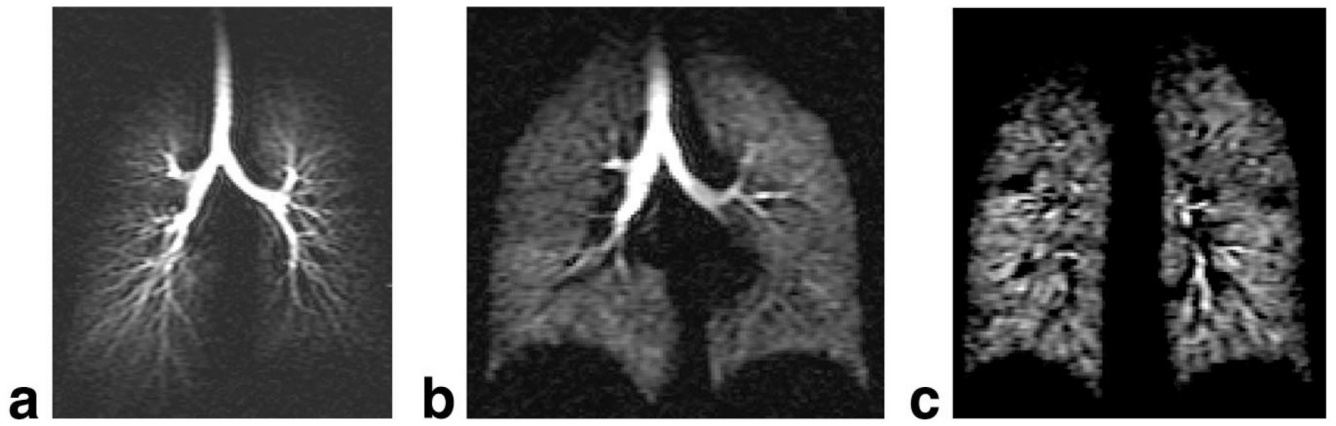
Representative dynamic coronal MR images. (a) Projection image; (b) Multislice image 7 of 13; (c) Multislice image 9 of 13.
